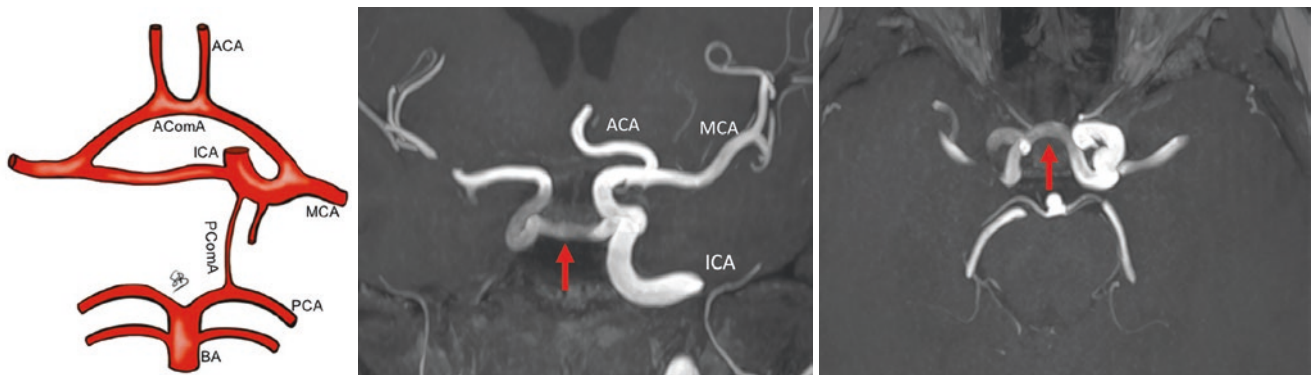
Type III B intercavernous anastomosis. The figure shows a clinical case (MRI TOF sequences) of right ICA agenesis, with compensation of the distal flow into the ACA and MCA granted by intercavernous
